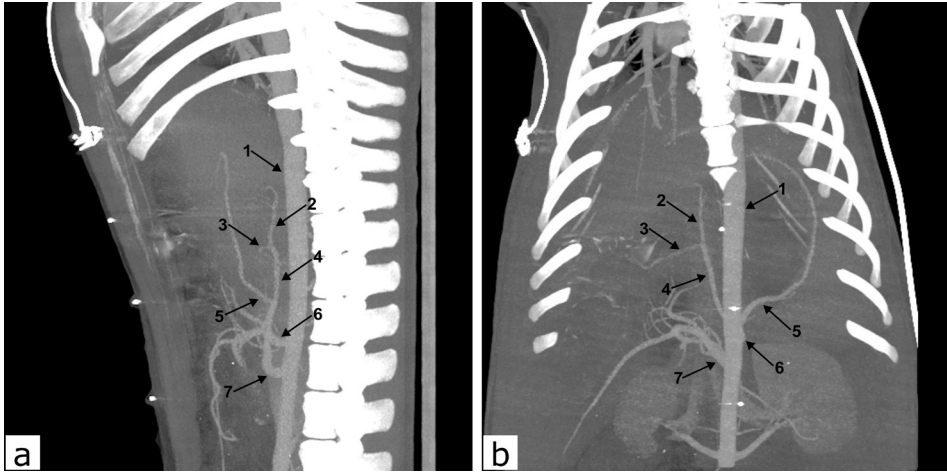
CT arteriography (maximum intensity projections). Lateral projections (a) and ventrodorsal projections (b): abdominal aorta (1), proper hepatic artery (2), gastroduodenal artery (3), common hepatic artery (4), splenic artery (5), celiac axis (6), and cranial mesenteric artery (7). The radiopaque objects on the abdominal wall are CT markers
